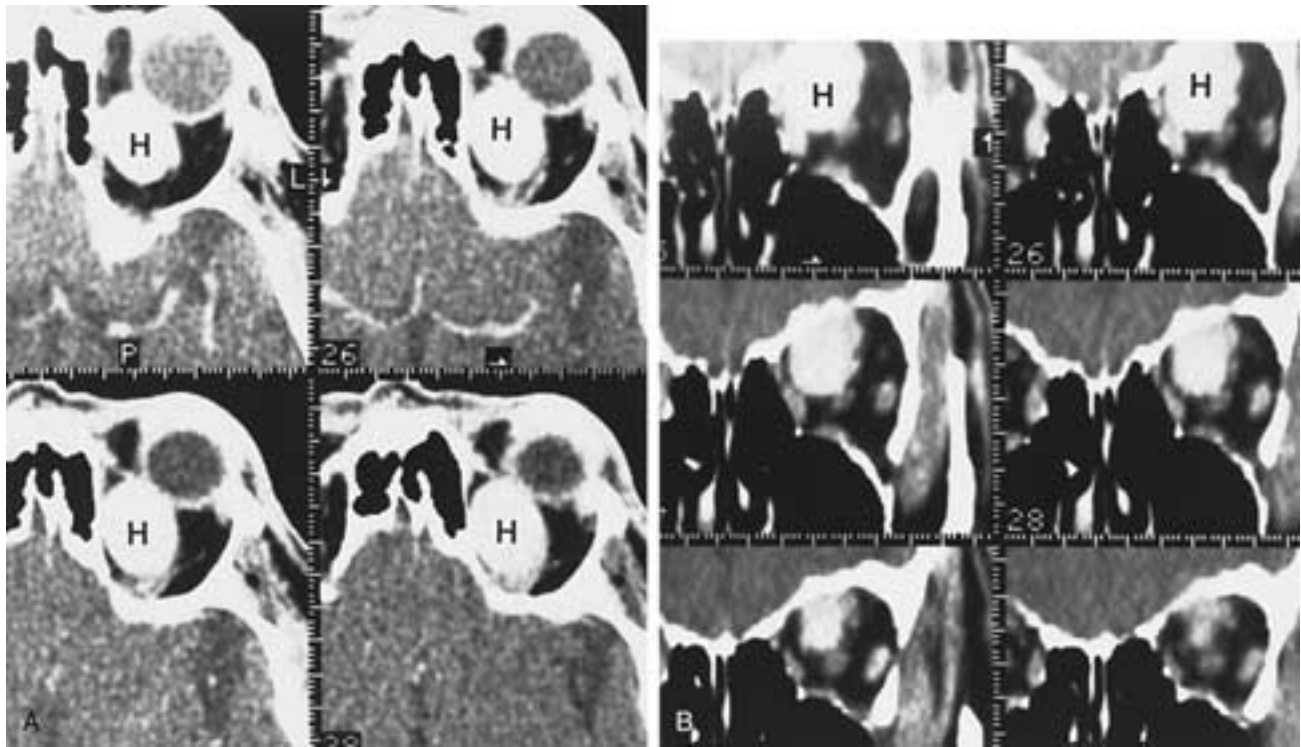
Cavernous hemangioma. A, Serial axial CT scan. B, Reformatted coronal CT scans. A and B show a well-defined intraconal markedly enhancing hemangioma (*H*).
